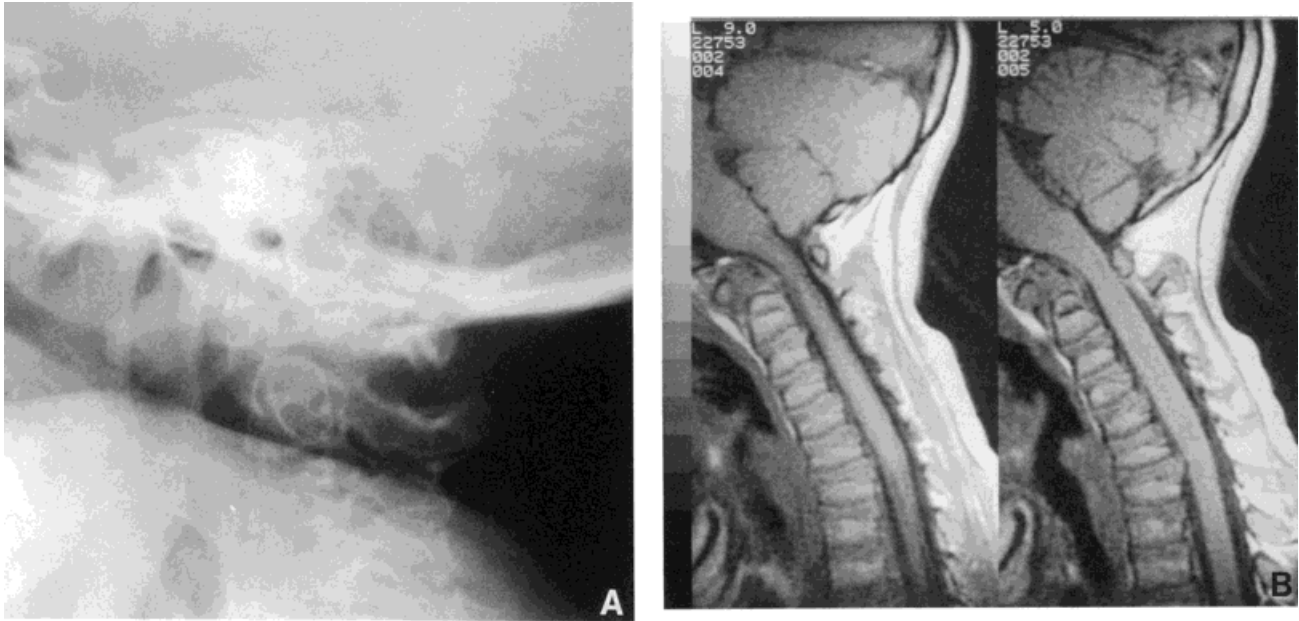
Seven-year-old with SED congenita. A, B: MRI shows typical C<sub>1</sub>C<sub>2</sub> subluxation with cord impingement.
